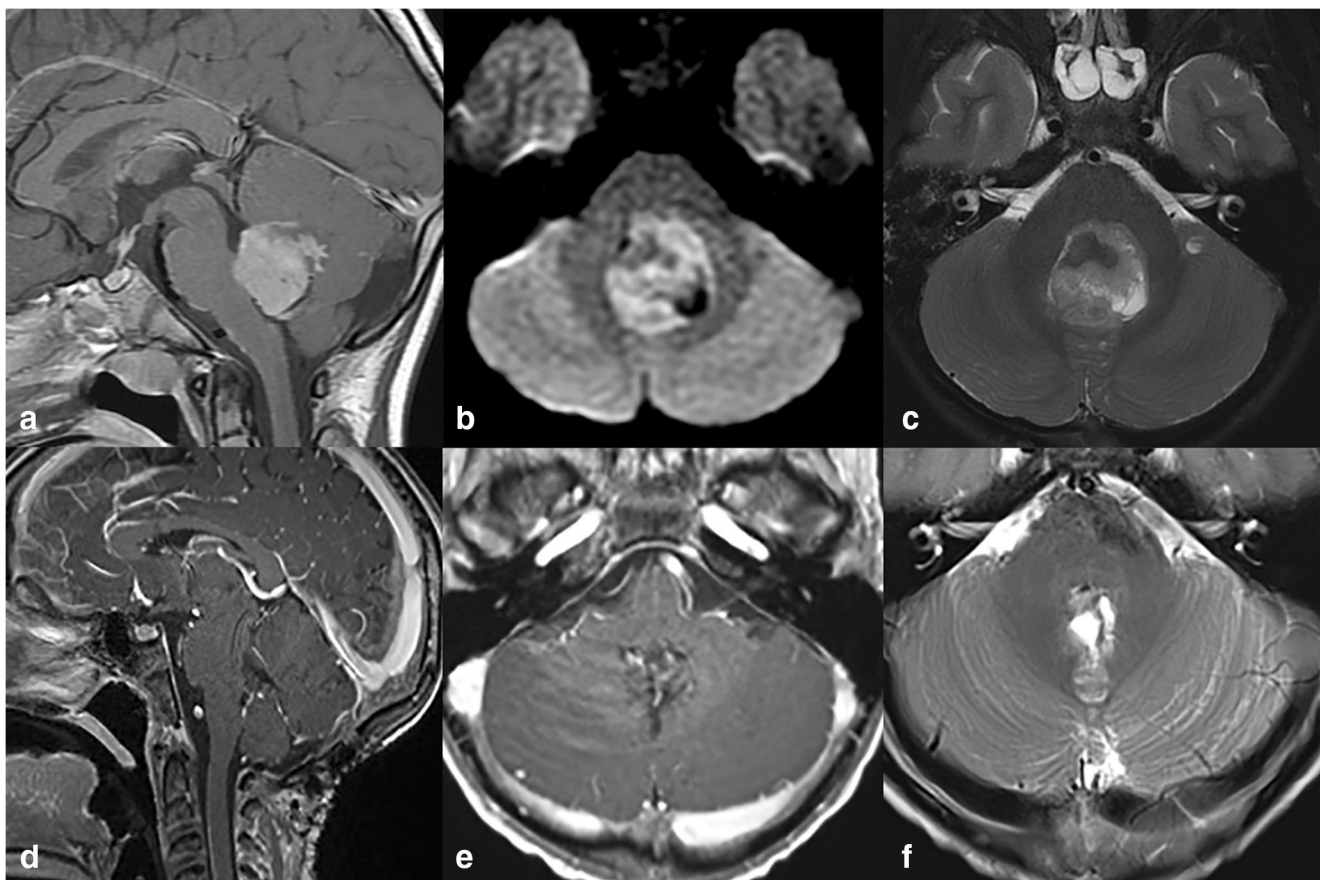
Case 4. MRI images for case 4; (a) sagittal post-contrast T1W depicts the original tumor in the fourth ventricle; (b) axial diffusion-weighted image and (c) axial T2W show diffusion restriction consistent
